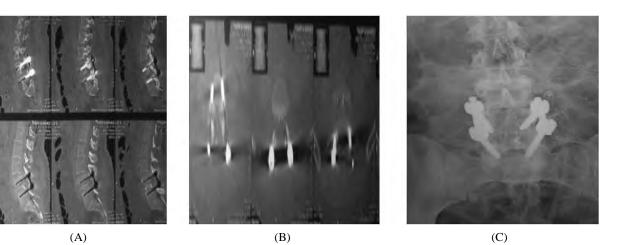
Case (2): Postoperative CT lumbosacral spine showing transpedicular fixation by screws with interbody fusion with lumbar cage and bone graft sagittal view (A) Axial view (B) Postoperative lumbar X-ray anteroposterior view (C).
